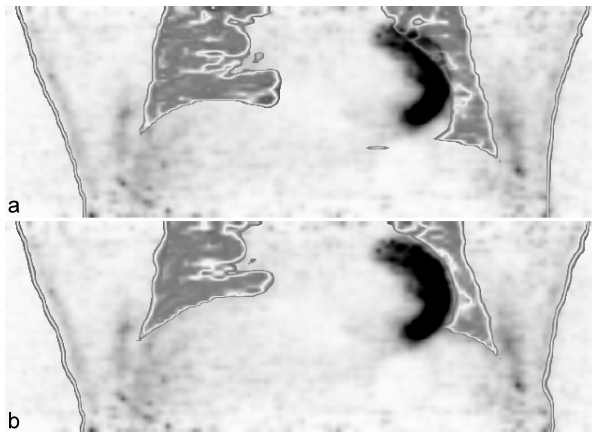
Transformation of the CT based μ -maps for accurate attenuation correction. The CT based μ -maps are shown overlaid on the PET data. Image a) shows that the μ -map does not corresponds to the respiratory phase of the PET data in the heart region. Image b) shows that after correction, the μ -map corresponds with the PET data and thus allows more accurate attenuation correction.
